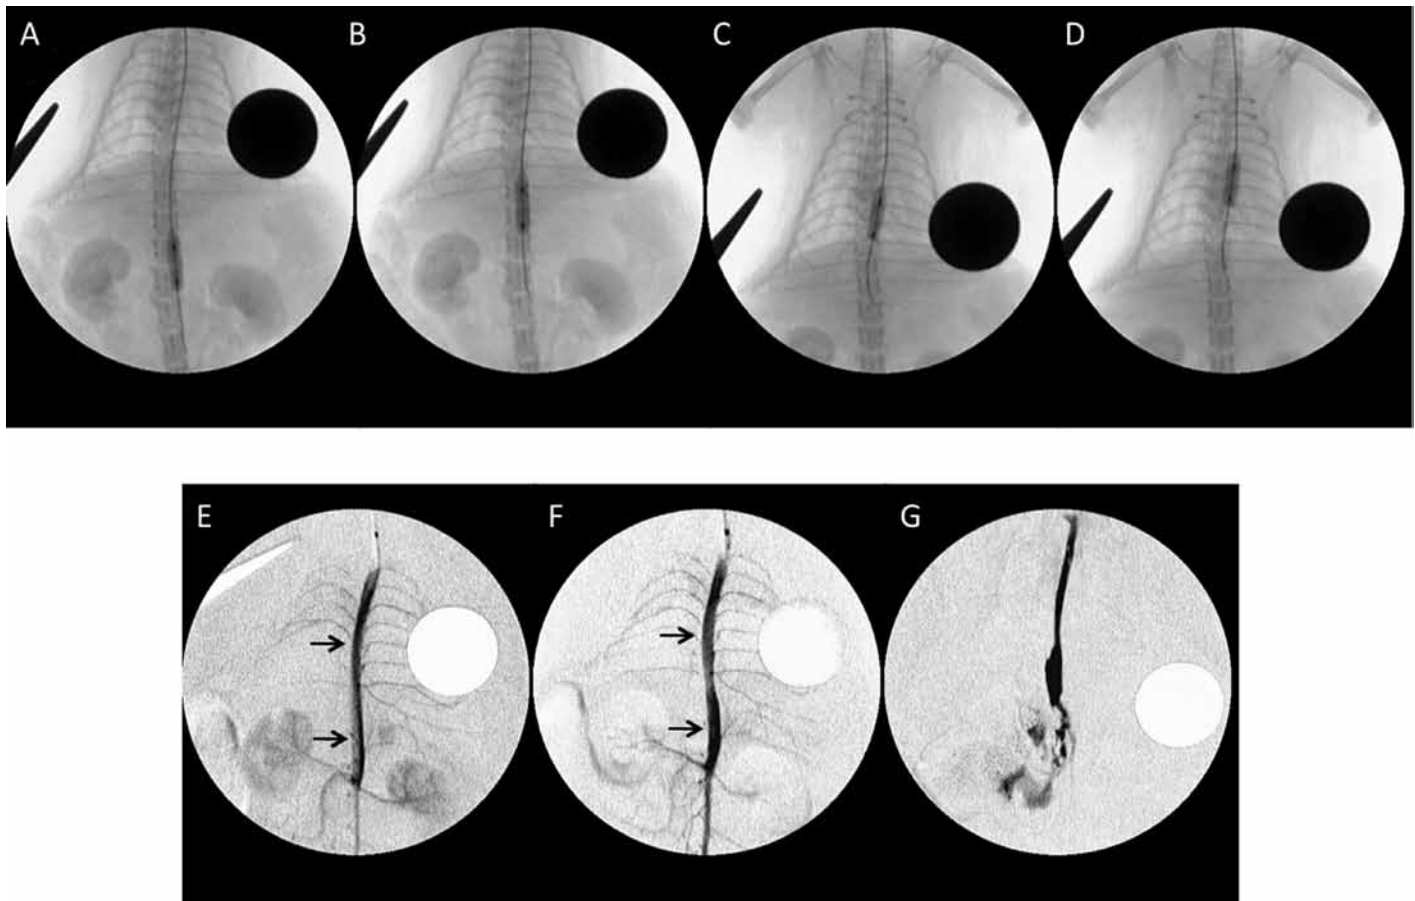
Anteroposterior radiographs demonstrating the balloon-injury technique. The balloon was (A) inflated above the renal bifurcation to a pressure of 2 atm (manual barometer) and then (B) pulled and rotated to just below the diaphragm, 4 successive times. (C) The thoracic aortic injury was done in similar fashion from above the diaphragm to (D) a few millimeters distal to the aortic arch. The radiopaque circle represents a 19-mm coin. Aortograms obtained (E) before and (F) after balloon injury demonstrate initial dilatation of the injured thoracic and abdominal aorta (arrows). (G) Occasionally, the induced injury would be complicated by aortic dissection and rupture (extravasation).
